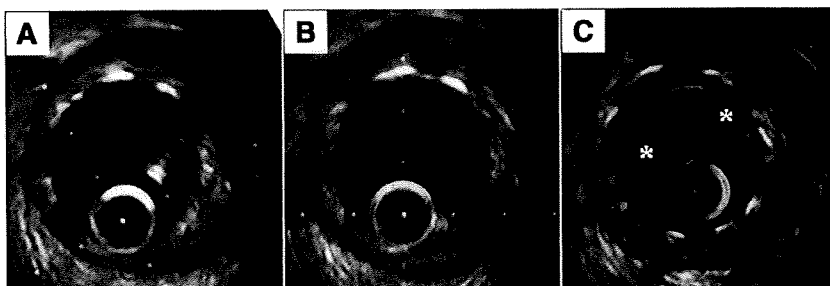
(A) Intravascular ultrasound (IVUS) after sirolimus-eluting stent implantation (stent cross-sectional area 7.6 mm^2). (B) Follow-up IVUS (stent cross-sectional area 7.7 mm^2). Note minimum intimal hyperplasia without incomplete apposition. (C) IVUS after predilatation for total occlusion (lumen cross-sectional area 2.6 mm^2 and stent cross-sectional area 7.7 mm^2). *Note heterogeneous mass in the stent.
